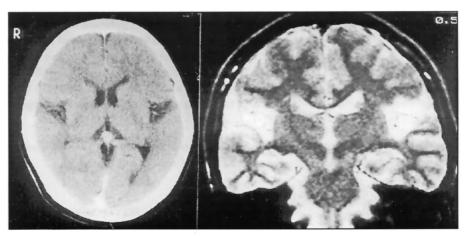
Case 2. A, Contrast-enhanced CT scan study also shows retractile, circumscribed, hypodense lesions on both opercula. B, MRI T2-weighted coronal image (2200/90/1) demonstrates hyperintense lesions at the frontal and temporal opercula.
